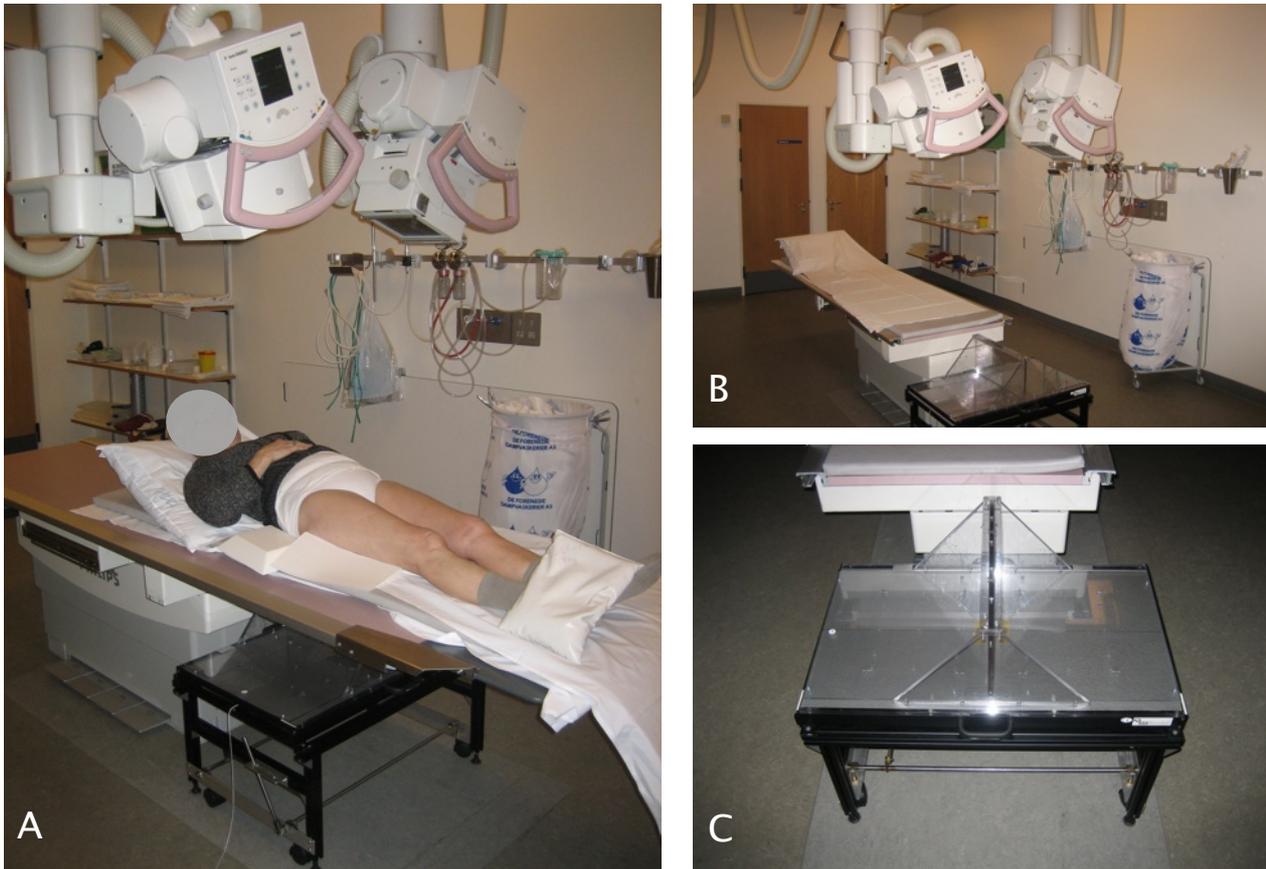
A–C. RSA examination with patient in supine position (A). Positioning of X-ray tubes in alignment with uni-planar cage (B and C).
